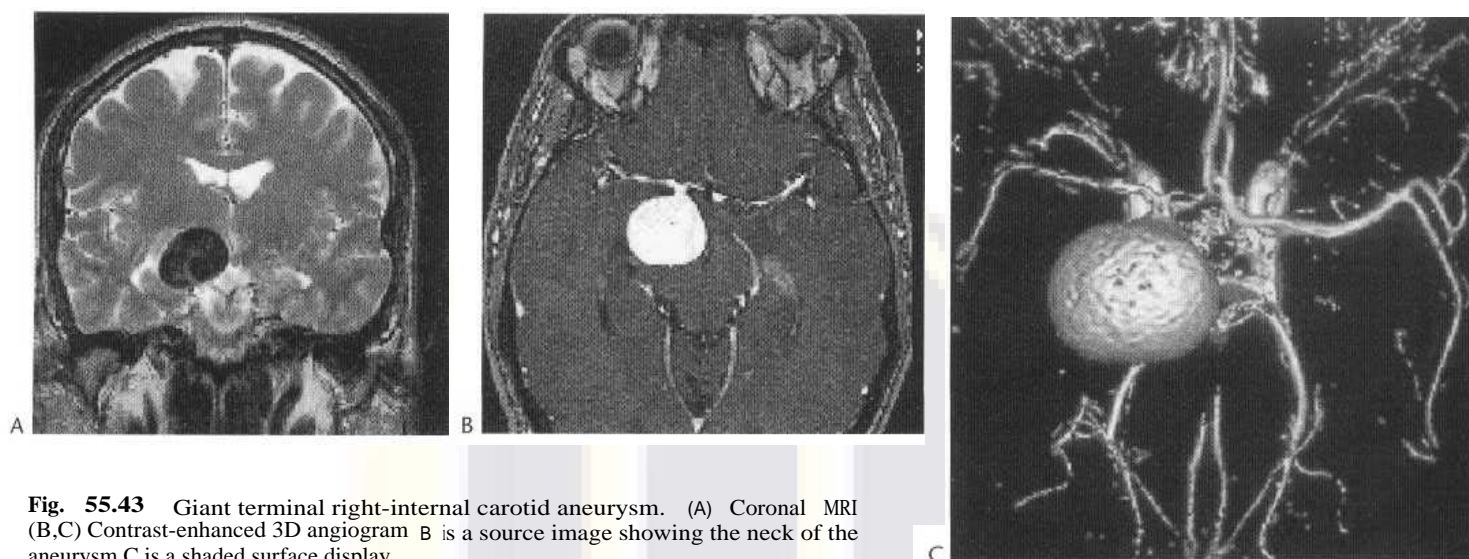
Giant terminal right-internal carotid aneurysm. (A) Coronal MRI (B,C) Contrast-enhanced 3D angiogram B is a source image showing the neck of the aneurysm C is a shaded surface display.
